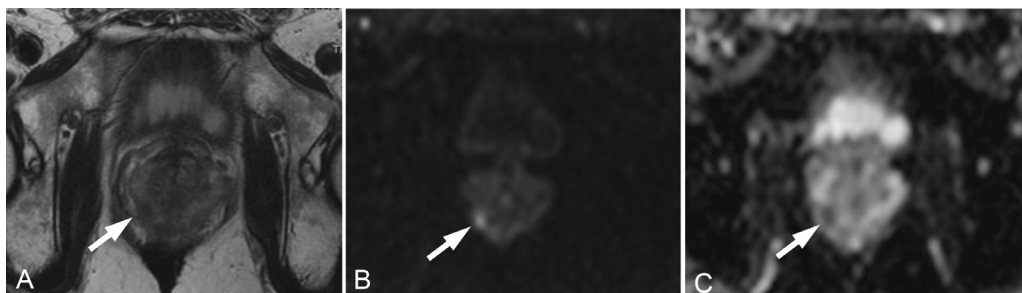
Prostate MRI. (A) T2-weighted image depicts a nodule of low signal intensity in the right peripheral zone at the 8 o'clock position. (B) Diffusion-weighted image shows a nodule of high signal intensity corresponding to that seen in the T2-weighted image. (C) Apparent diffusion coefficient value map depicts an area of low signal corresponding to the nodules seen on the T2-weighted and diffusion-weighted images.
